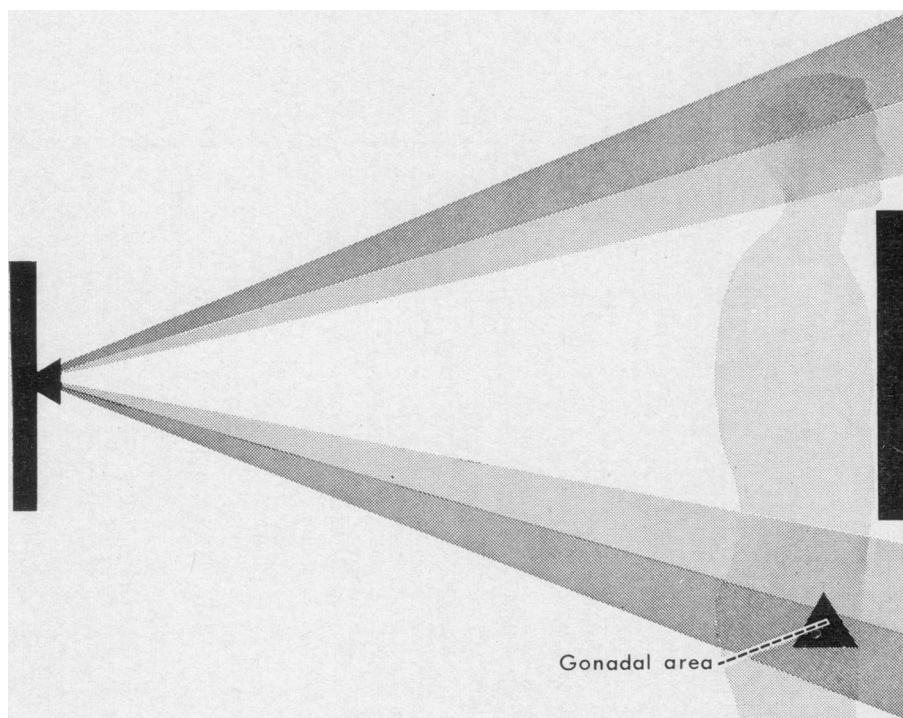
Excessive X-ray beam diameter.
